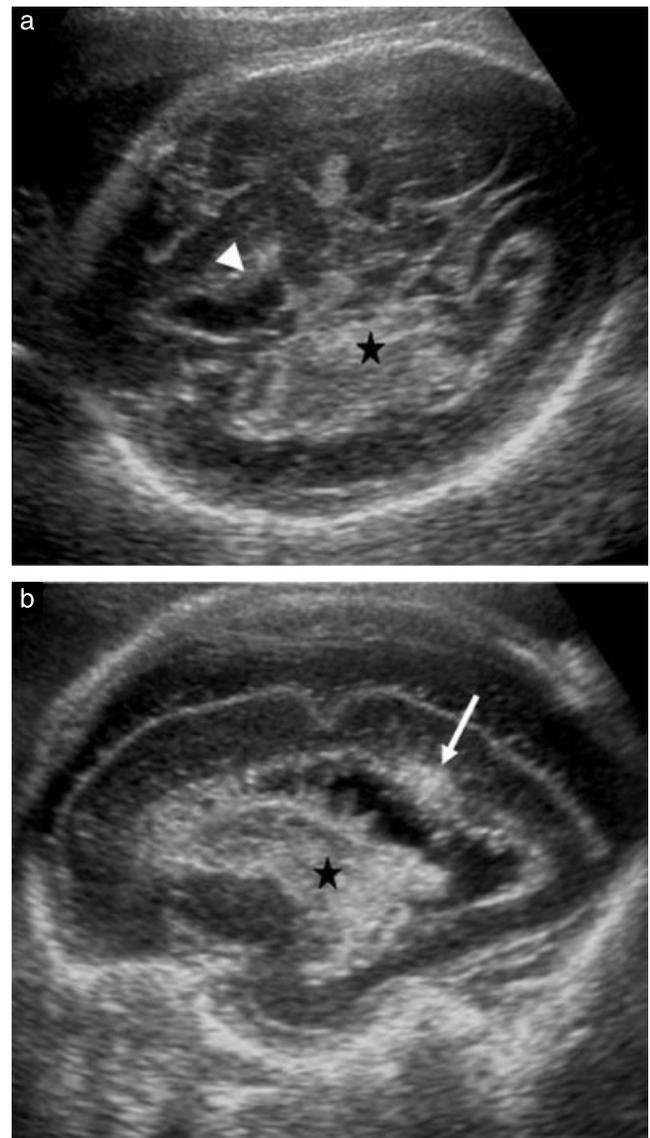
Ultrasound images of fetal intracranial hemorrhage at 28 weeks' gestation demonstrating enlarged lateral ventricles with intraventricular hemorrhage and hyperechoic and irregular ventricular borders. (a) Axial view, showing involvement of left subependymal area (arrowhead) and hemorrhage (star) in the right ventricle and adjacent thalamus. (b) Right parasagittal view, showing massive hemorrhage (star) involving the thalamus and extending to the adjacent parietal parenchyma (arrow) with ependymal rupture.
